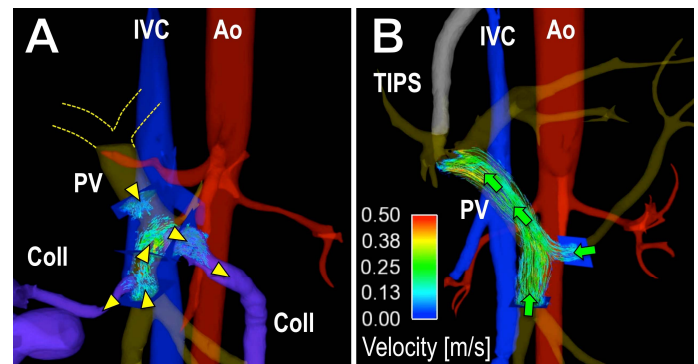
4D-flow MRI visualization of hemodynamics in the portal vein before and after TIPS placement in a patient with portal hypertension. (A) Retrograde hepatofugal flow (arrow heads) into collaterals (Coll) is seen in the portal vein (PV) pre-TIPS. There was no detectable flow in the right and left portal vein (indicated by dotted lines). (B) Post-TIPS the flow reversed, now hepatopetal (arrows) in the portal vein, whereas no flow was detectable in collaterals. Ao=Aorta, IVC=inferior vena cava.
